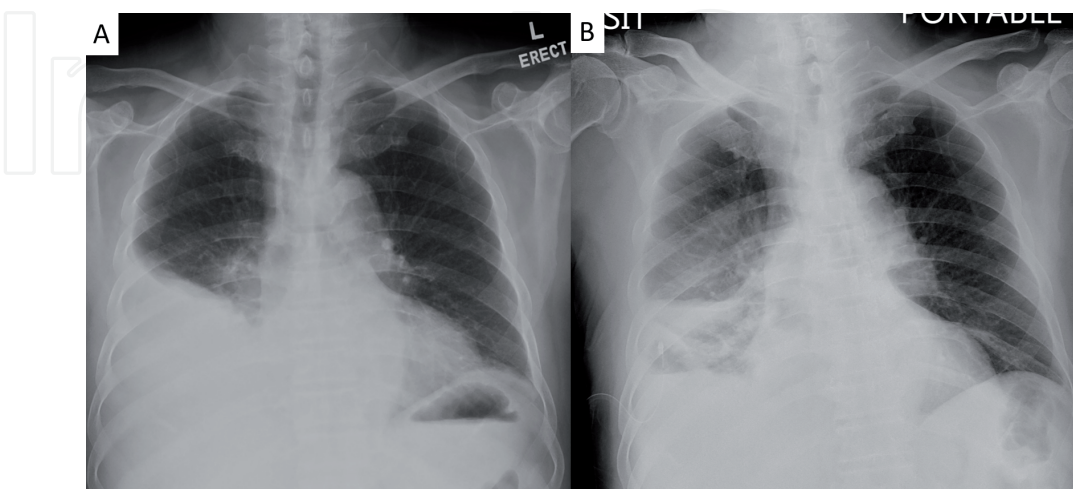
(A) Moderate right pleural effusion that has accumulated for 3 days following CT-guided microwave ablation of a right lower lobe lung tumor. The patient had low grade fever and complained of shortness of breath. (B) partial drainage of the effusion by a medium bore chest drain. The pleural fluid was exudative but sterile, and the patient was discharged home after a course of antibiotics and complete drainage of the effusion.
